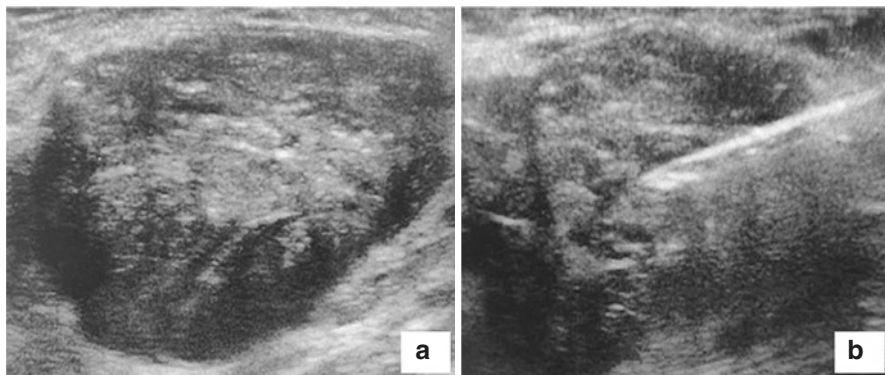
Ultrasound guide breast biopsy of a mass. (a) The 14G core biopsy needle is inserted and then fired (b) into an irregular heteroechoic mass, to obtain tissue cores
